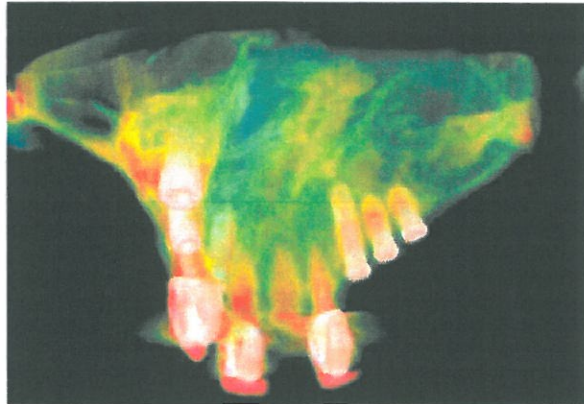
Maxilla (CT scan), alternative view
